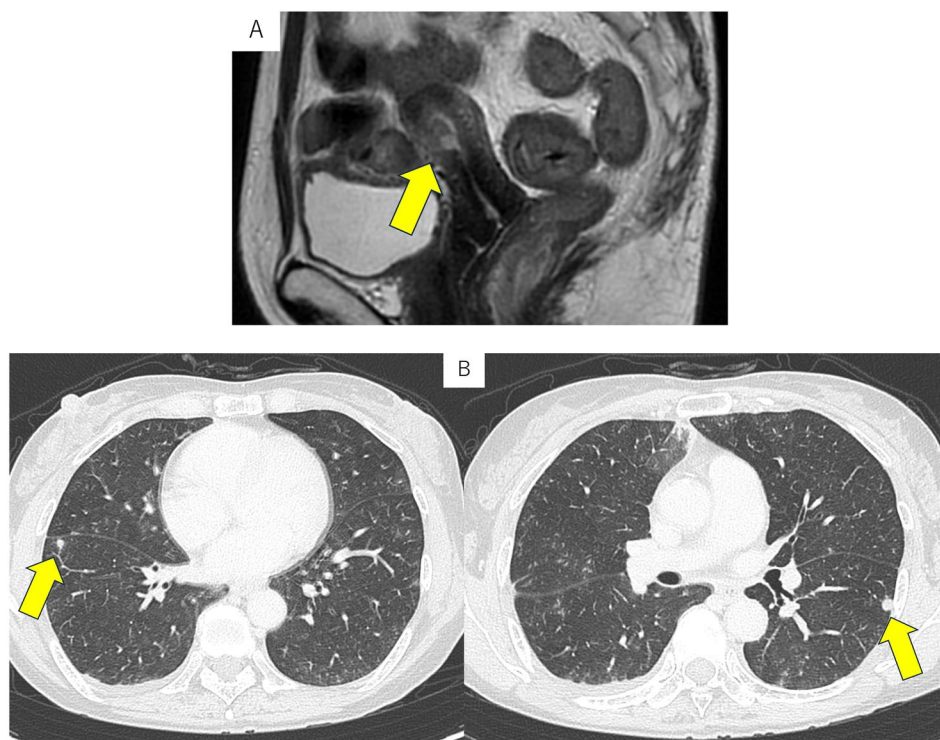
Pretreatment pelvic MRI and contrast-enhanced CT. (A) Pelvic MRI shows a solid intrauterine mass measuring 12×10 mm with superficial myometrial invasion and strong enhancement. (B) Contrast-enhanced CT reveals multiple bilateral pulmonary metastases.
